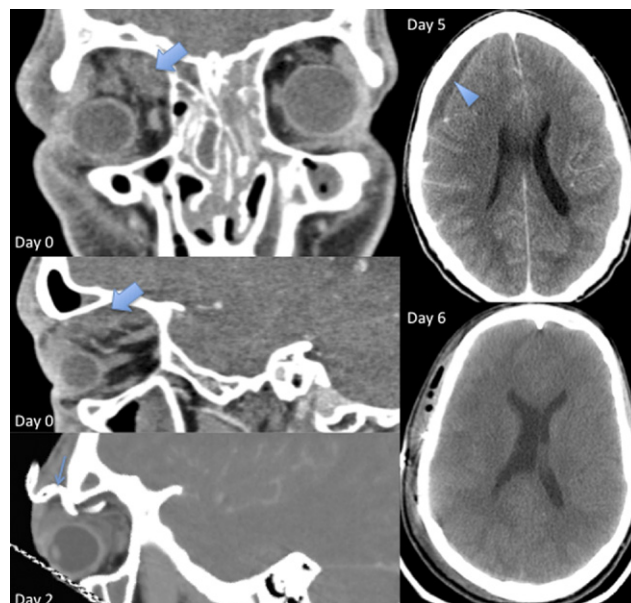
CT of the head and orbits. Used with permission of Seongmu Lee, MD, MD, Cullen Eye Institute, Department of Ophthalmology, Baylor College of Medicine, Houston, TX.
